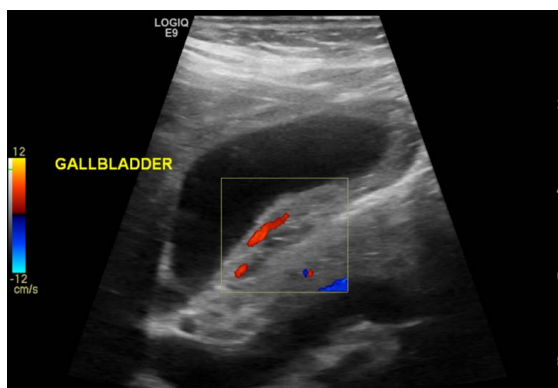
Grey-scale and Doppler ultrasound showed significant gallbladder wall thickening with cystic spaces and internal vascularity
